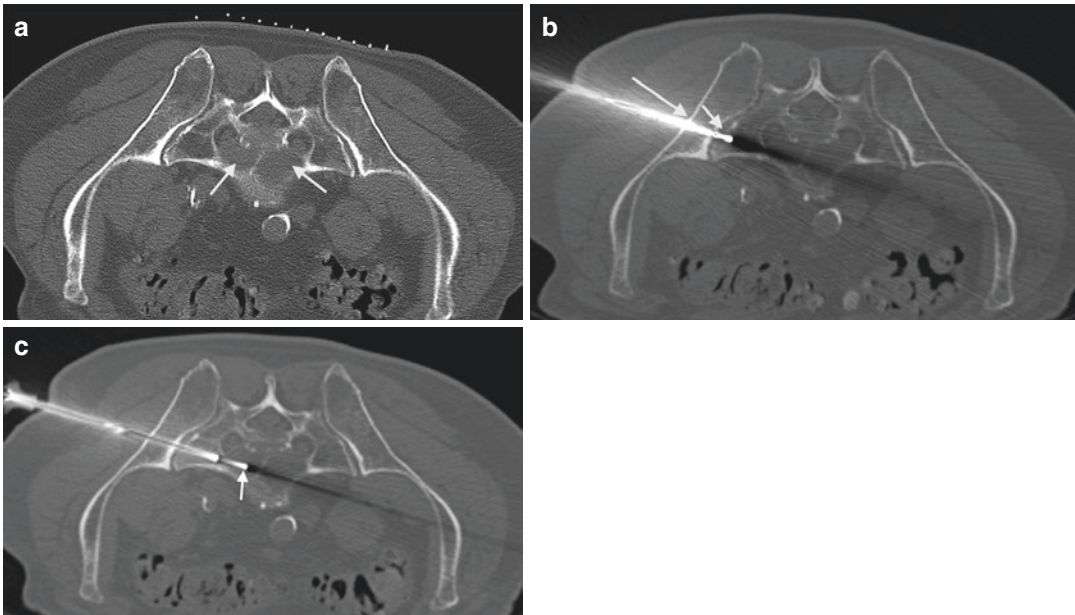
A 79-year-old male with history of colon cancer and low back pain. Axial CT image (a) during biopsy procedure shows the skin grid in place and a lytic lesion within the sacral promontory (arrows). A posterior approach was not feasible in this case; therefore, a lateral (b) or trans-iliosacral approach (large arrow) was used to
